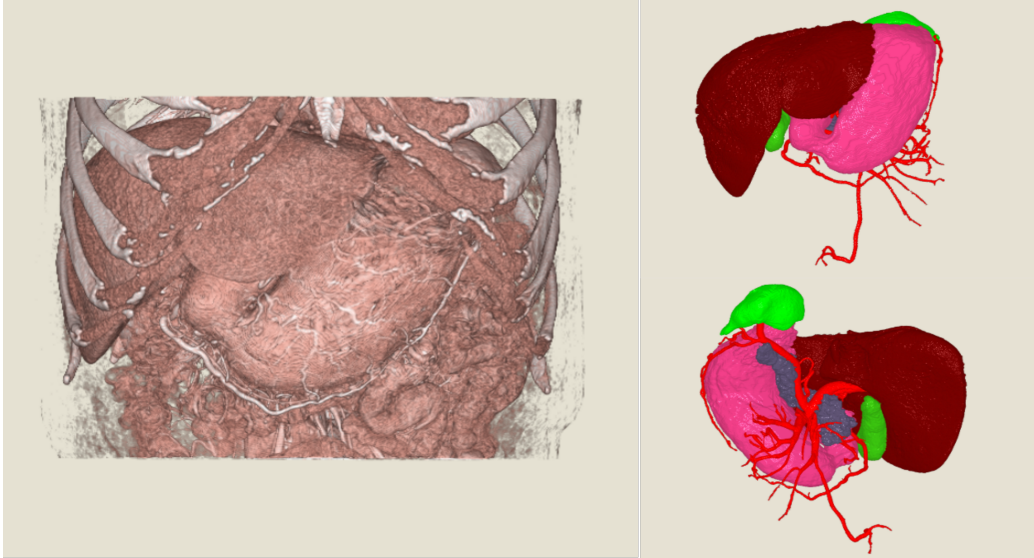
One example of multiple abdominal organs. Left is volume rendering of abdominal CE-CT data. Right is volume rendering of annotated labels of multiple organs
